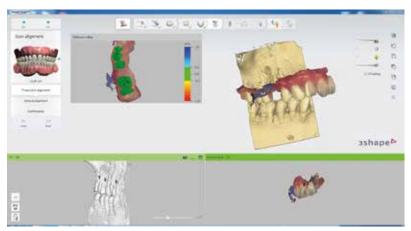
STL file is imported and combined with DICOM data from the CBCT scan
